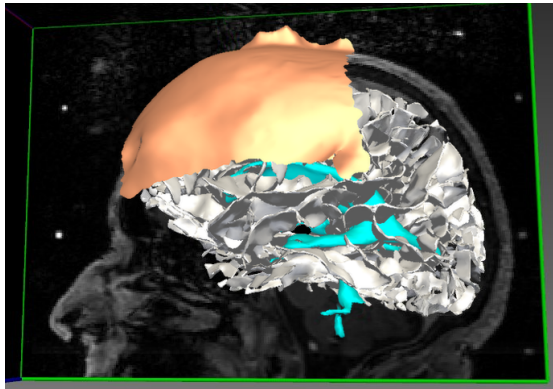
Snapshot showing the data as a complete 3D scene, for the same patient as in Fig. 1. In the background, the preoperative MRI. In white, the cortical sulci. The ventricles are in blue and the target is in black. On the top of the head, the initial zone is in orange.
